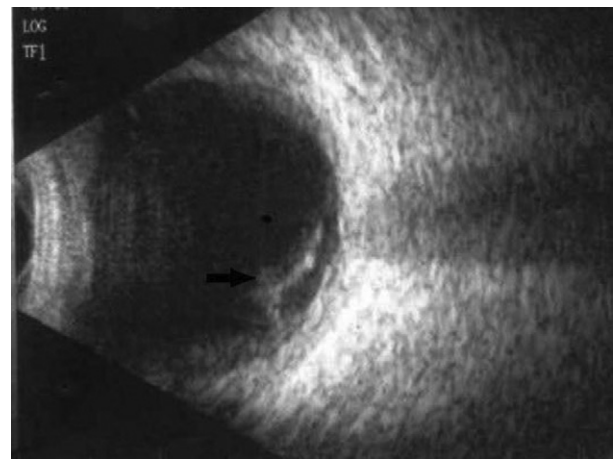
Inferoposterior retinal detachment demonstrated by portable ocular ultrasonography.
